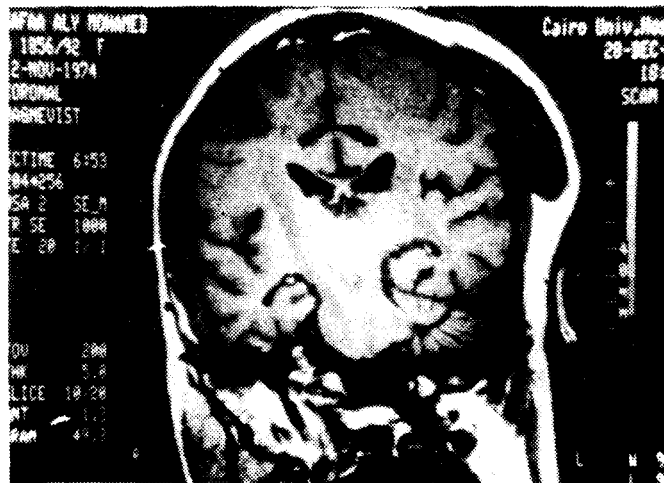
Post contrast MRI in the coronal projection revealed and homogenously and density enhancing pineal body tumour obstructing the 3rd ventricle with consequent supratentorial hydrocephalic (moderate degree) changes.
